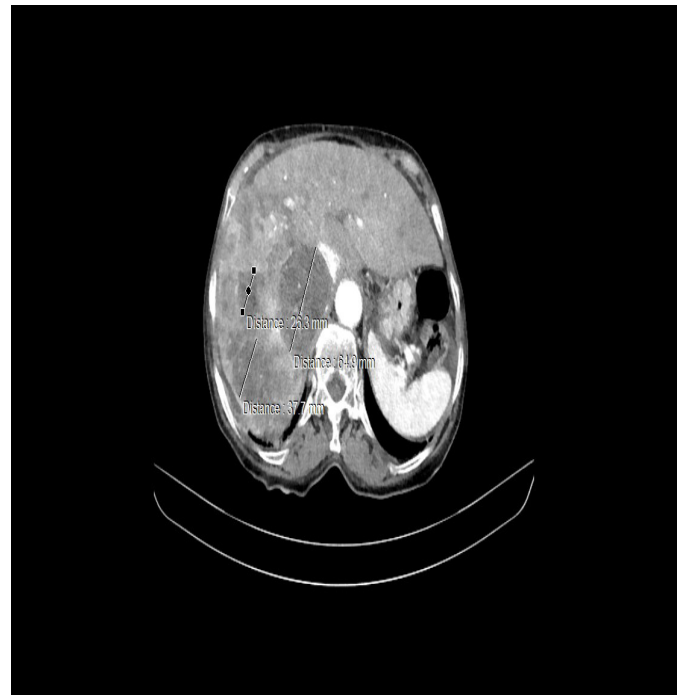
Thoracic CT, showing a heterogeneous liver with multiple nodules of more than 20 mm, the largest of which is 64.9 mm (blue arrows). Imaging Service CHU Ibn Sina.
